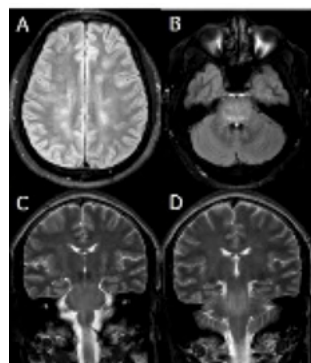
A. T2-weighted axial MRI / FLAIR shows multiple bilateral hyperintense flocculating lesions in the white matter of the semioval center and corona radiata. B. T2-weighted axial MRI / FLAIR shows hyperintense lesions in the bilateral pontine tegme
